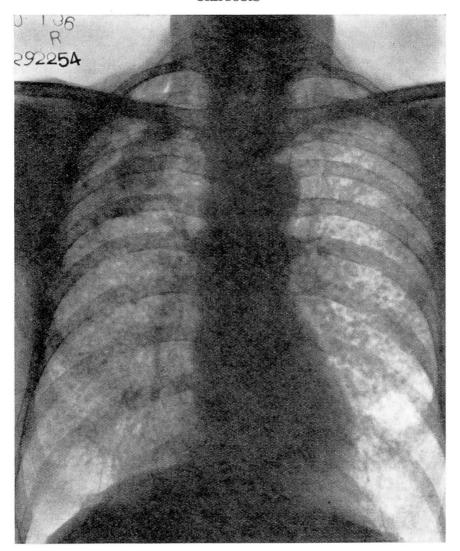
Roentgenogram of the chest.
